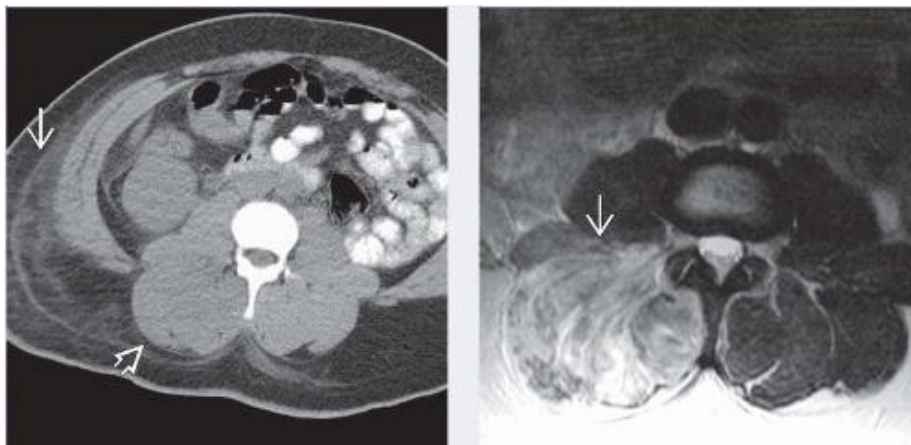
Rhabdomyolysis: Left CT/Right: MR T2 [48]
